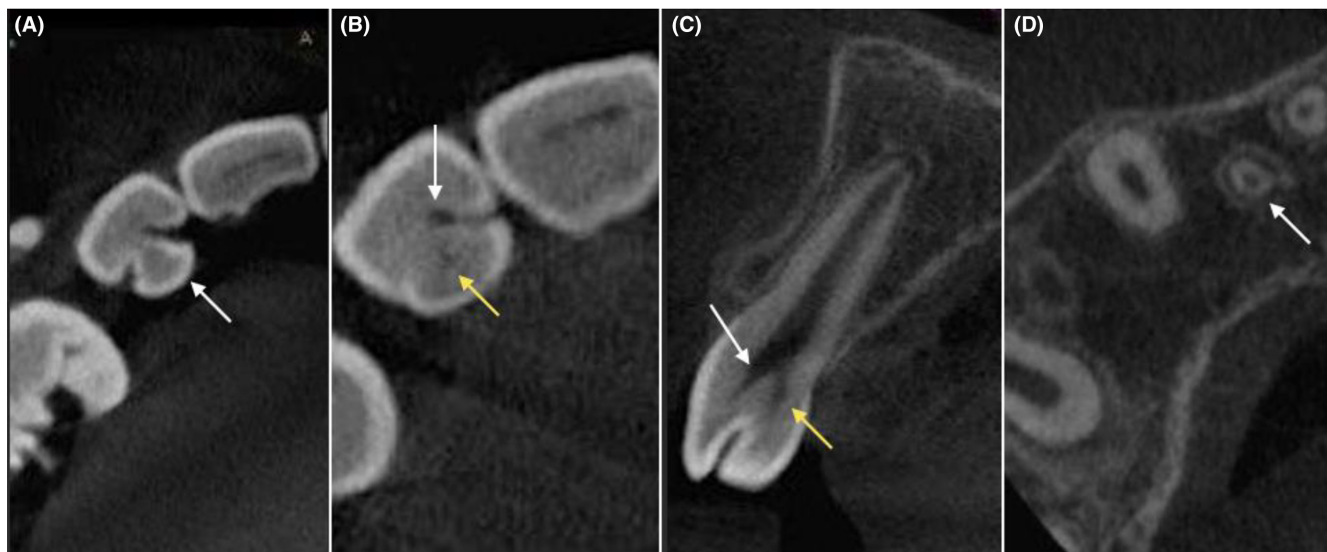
CBCT scan showing (A) the presence of a well-defined projection (arrow) of enamel and dentine on the palatal aspect of the maxillary right lateral incisor on an axial view, 5 mm from the incisal tip; (B) axial view; (C) sagittal view at the cervical level of the tooth showed the main root canal system in the center (white arrow) as well as an accessory canal (yellow arrow) on the palatal aspect of the root branching from the main root canal system; and (D) AXIAL view 0.5 mm from the root tip revealed an immature open apex.
